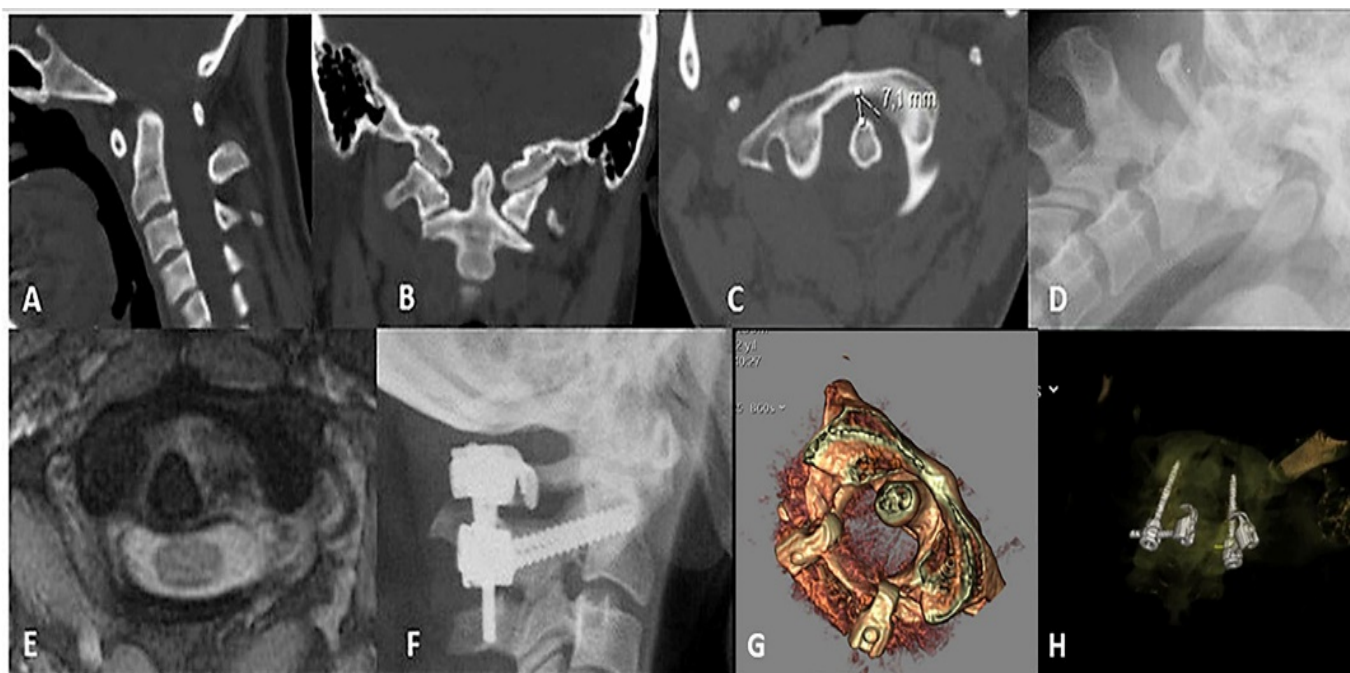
27/F, motor vehicle accident, neurological evaluation intact, Suboccipital and Neck pain: Preoperative sagittal axial coronal planes CT imaging (A, B, C), flexion lateral radiography (D), T2 axial MRI image (E) (Transverse ligament rupture) and postoperative lateral radiography (F) and 3D CT reconstruction images (G, H)
